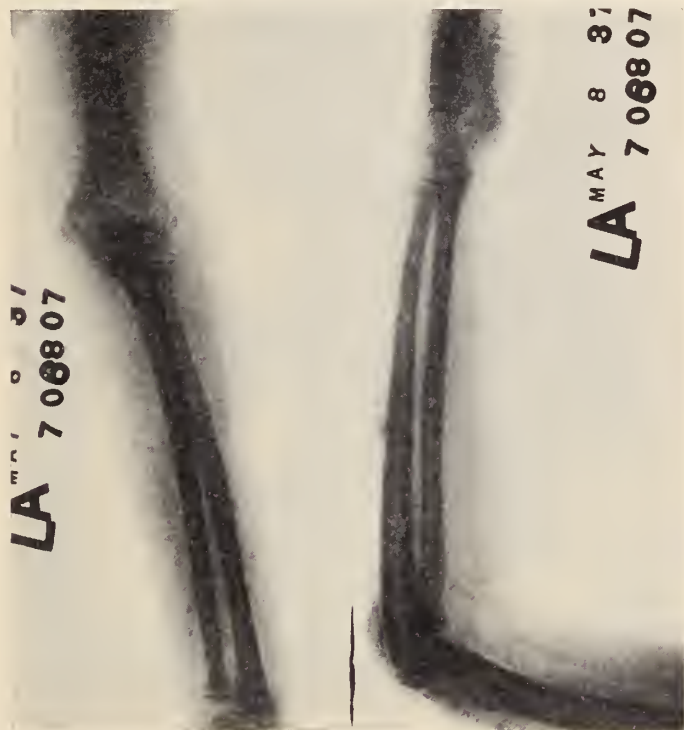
Roentgenogram taken May 8, 1937. Calcifications in the subcutaneous tissue of the upper extremities and calcified arteries are marked.
